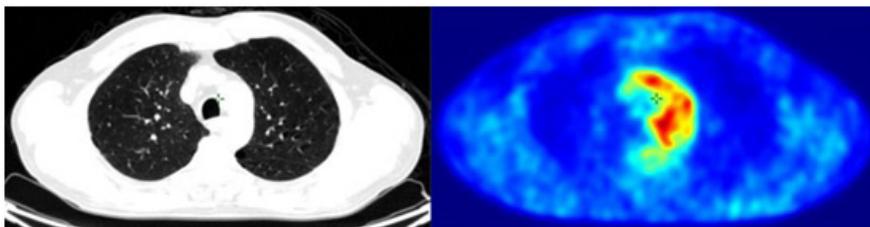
A follow-up PET-CT scan/ September 2019 without recurrences and metastases.
